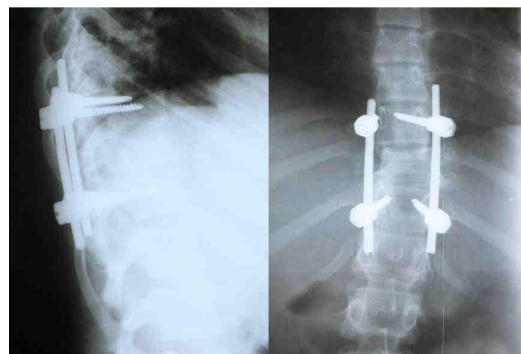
Postoperative radiographic aspect
